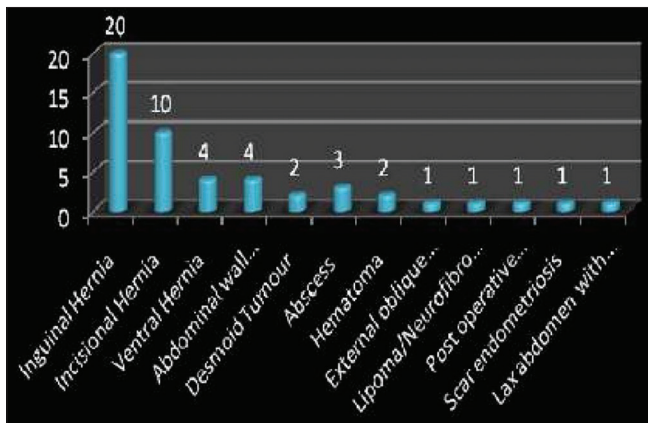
Spectrum of anterior abdominal wall lesions detected by high-resolution ultrasound sonography
